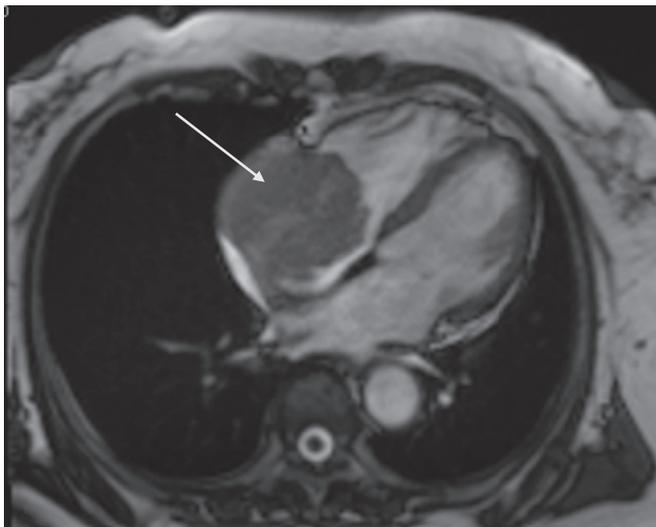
Magnetic resonance imaging of the primary cardiac DLBCL patient tumor. MRI scan revealed heterogeneous soft-tissue density located in the enlarged right atrium with a clear margin. The white arrow shows the tumor mass.
